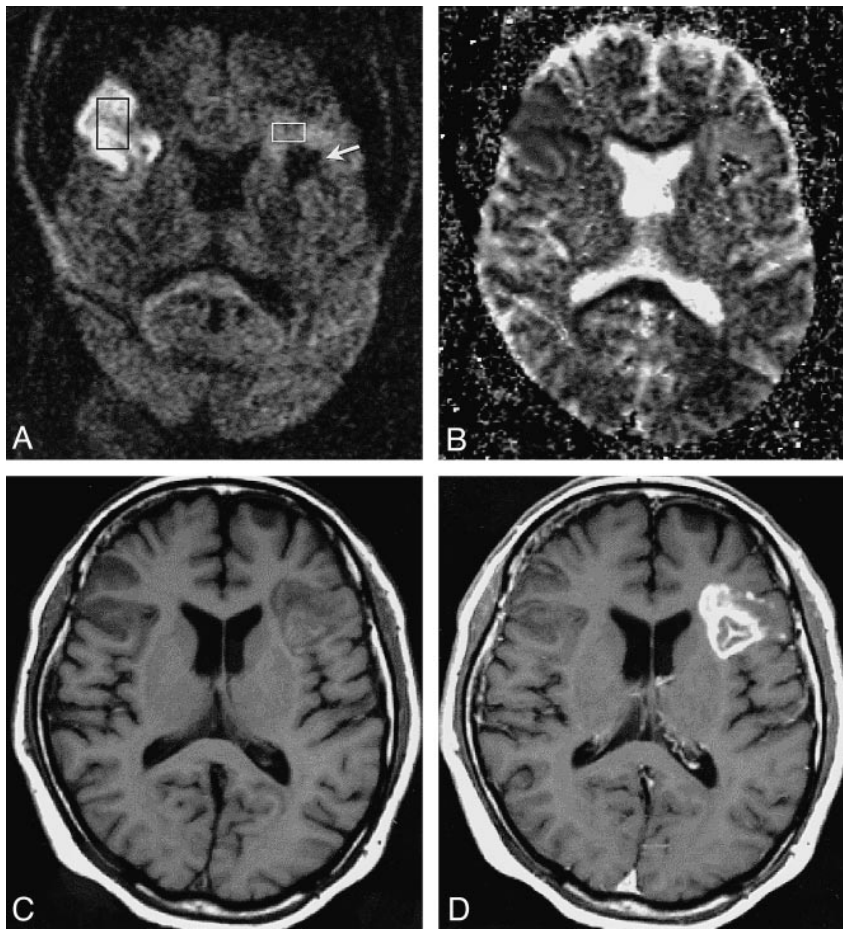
A–D, Embolic infarcts at 3 days (right frontal) and 6 days (left frontal) after stroke onset. Right frontal infarct reveals marked high intensity on the diffusion-weighted image (A), and a low ADC (B) and little enhancement (C, before contrast; D, after contrast) on the T1-weighted SE images. *Black rectangle* indicates the ROI placed in the core region (A). Anterior portion of left frontal infarct reveals a mild high-intensity signal on the diffusion-weighted image (A) and a moderately high ADC (B) and marked enhancement (C and D) on the T1-weighted SE images. The posterior portion has extremely low intensity on the diffusion-weighted image because of hemorrhage (arrow in A). *White rectangle* (A) indicates the ROI placed in the anterior portion.
